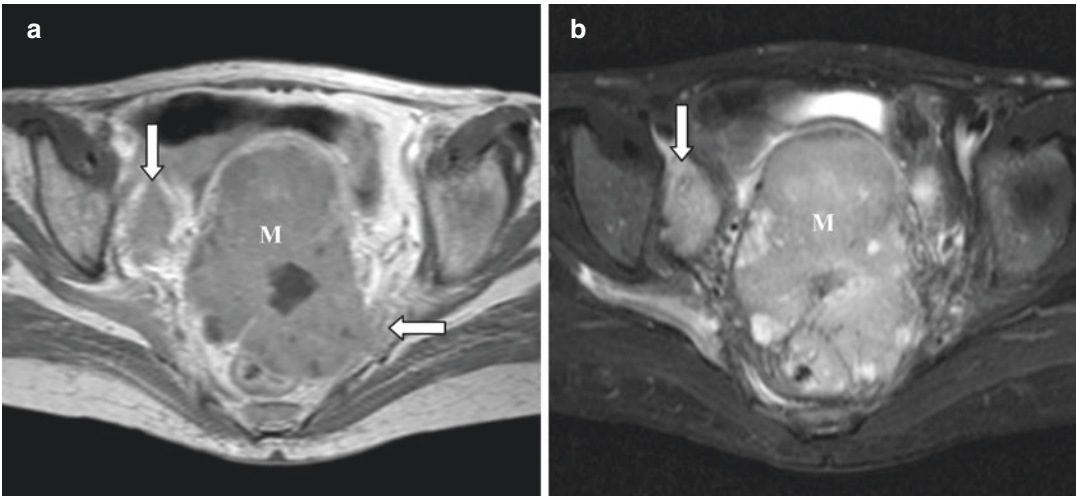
Cervical cancer with pelvic side wall invasion. (a, b) Axial T1W and T2W MR images showing a large lobulated cervical mass (M) with areas of necrosis. Mass infiltrates bilateral parametrium, left pelvic side wall (horizontal arrow) and also infiltrates the anterior rectal wall. There is associated right iliac lymphadenopathy (vertical arrows)
